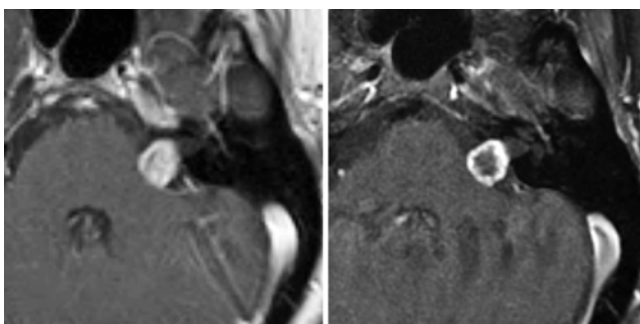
Stereotactic radiosurgery. Left: Pretreatment axial post-contrast fat-suppressed T1-weighted MRI study showing a left vestibular schwannoma that contains minimal nonenhancing components. Right: Axial post-contrast fat-suppressed T1-weighted MRI study obtained 1 year after stereotactic radiosurgery, showing interval development of an extensive area of central nonenhancement.
